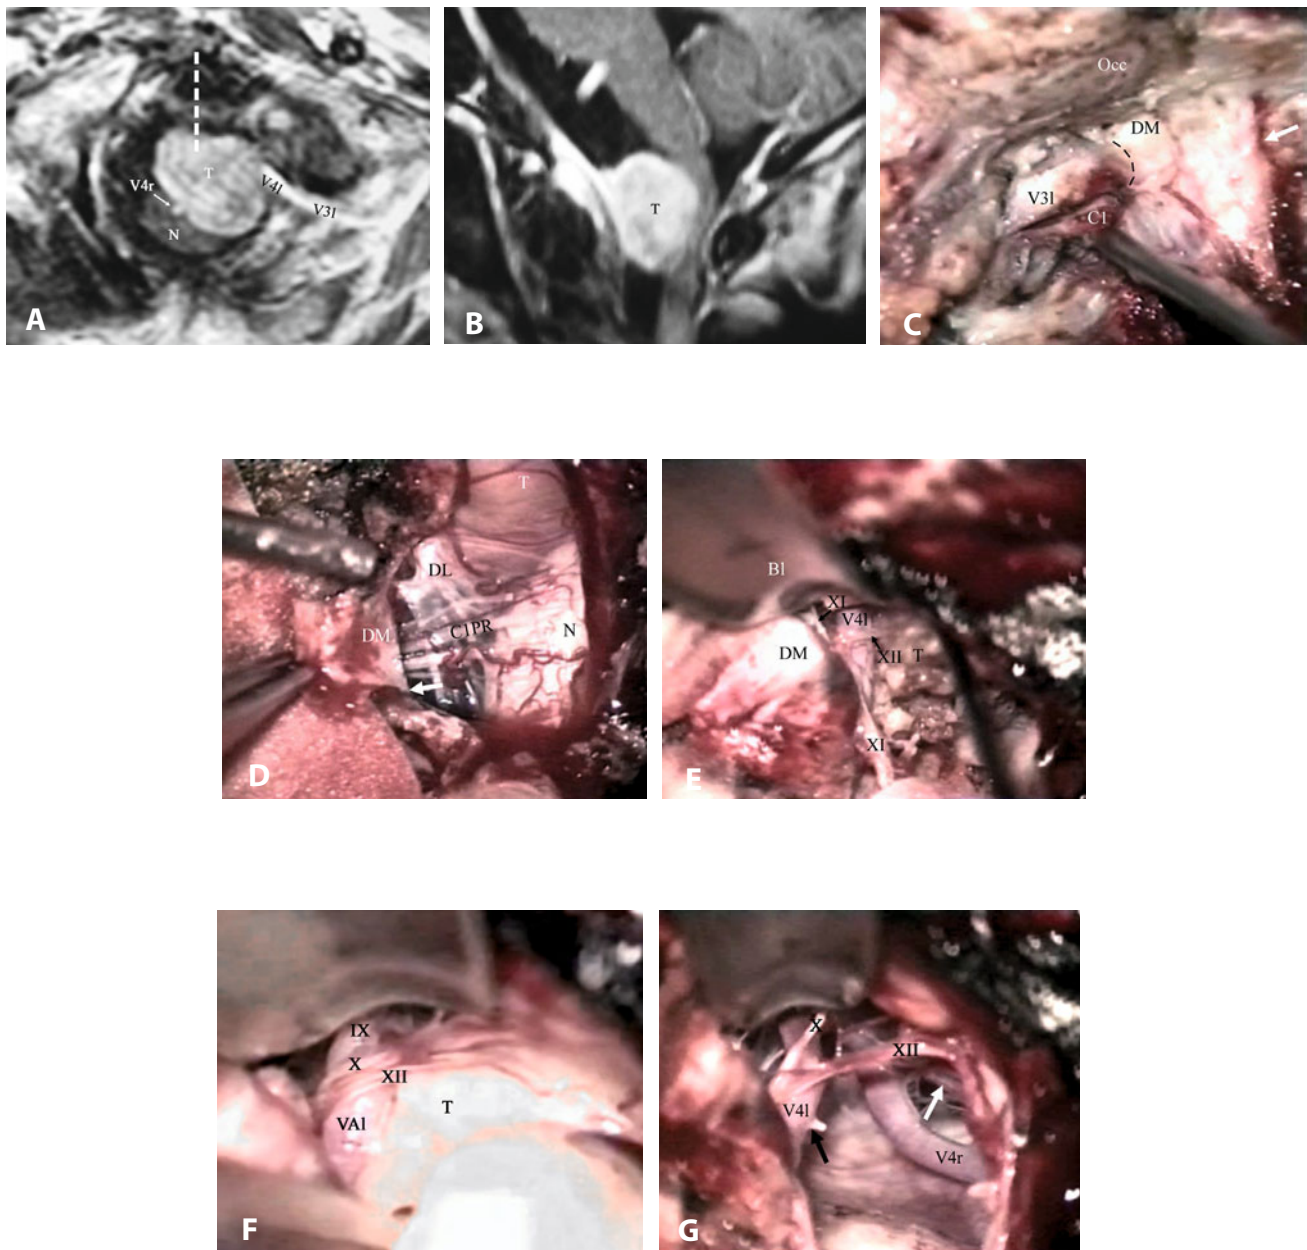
Anterior foramen magnum meningioma. A. Axial T1-weighted MRI with gadolinium. This meningioma inserts on both sides of the midline. Notice large lesions create by itself an extended surgical corridor (*double arrow*). Consequently, bone resection of the foramen magnum lateral wall can be unnecessary or at maximum limited to one-fifth (*dotted line*). The larger the lesion, the more important is the compression of the neuraxis, which is displaced contralaterally to the base of insertion. B. Sagittal view. M: meningioma. N: neuraxis. V4l: left vertebral artery V4 segment. V4r: right vertebral artery V4 segment.
